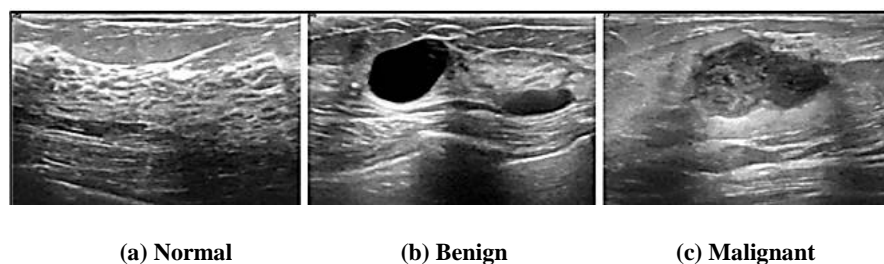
Breast mass ultrasound images.
